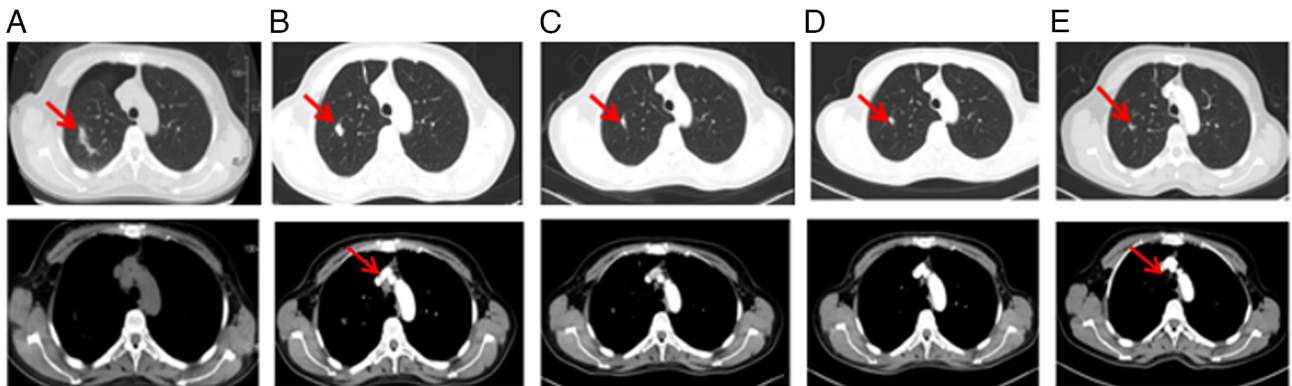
Lung CT scans indicating the tumors of the patient before and after osimertinib treatment. (A) May 2016: Before osimertinib treatment and at the end of second-line chemotherapy treatment (arrow points at the ablated right lung lesion and enlarged mediastinal lymph node). (B) June 2016: One month after osimertinib treatment (arrow points at the ablated right lung lesion and shrunk mediastinal lymph node). (C) November 2016: Six months after osimertinib treatment (arrow points at the ablated right lung lesion). (D) November 2018: 30 months after osimertinib treatment (arrow points at the ablated right lung lesion). (E) March 2023: 82 months after osimertinib treatment (arrow points at the ablated right lung lesion and shrunk mediastinal lymph node).
